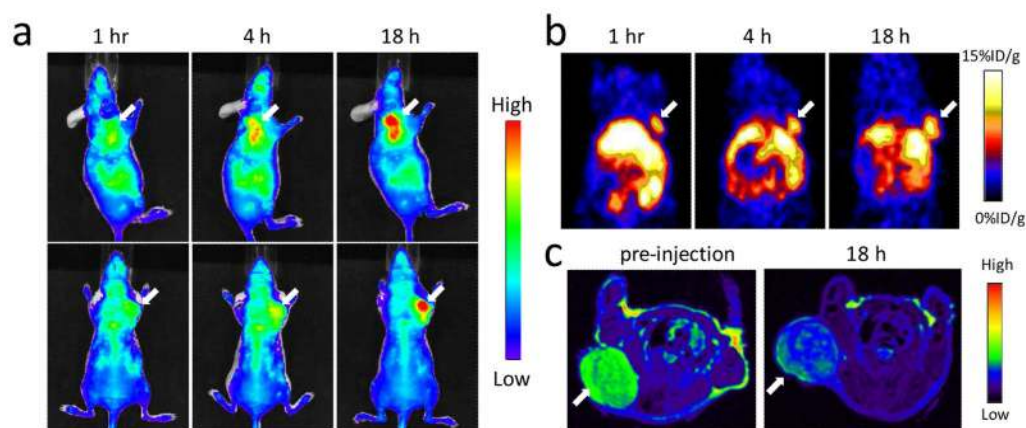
MRI/NIRF/PET tri-modal imaging (a, NIRF; b, PET; c, MRI) with HINPs that were conjugated with both ^{64}Cu -DOTA and Cy5.5.
